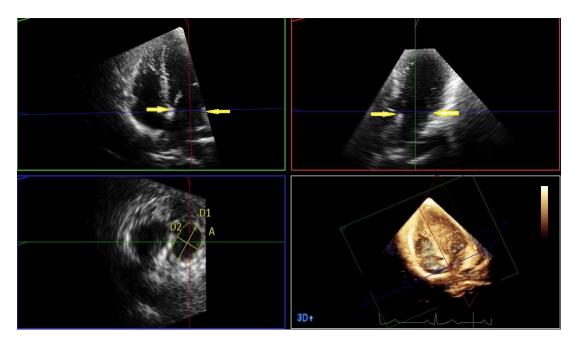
Anterior-posterior (MV3D1) and medial-lateral (MV3D2) diameters and cross-section area of the mitral valve annulus (in en-face views, applying 3D echocardiography and MV AREA are evaluated
